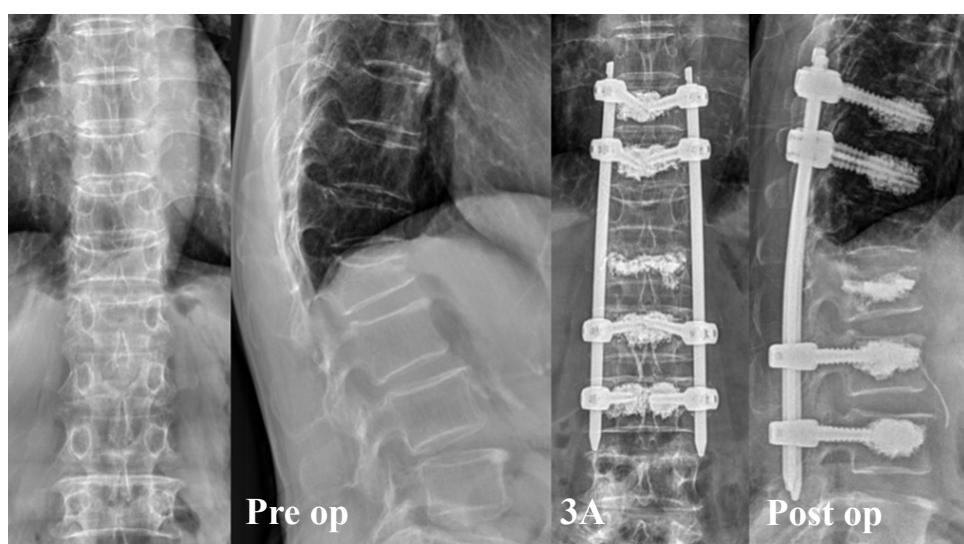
The spinal x-ray of a patient before (3A) and after (3B) the MIS CAPT operation.
